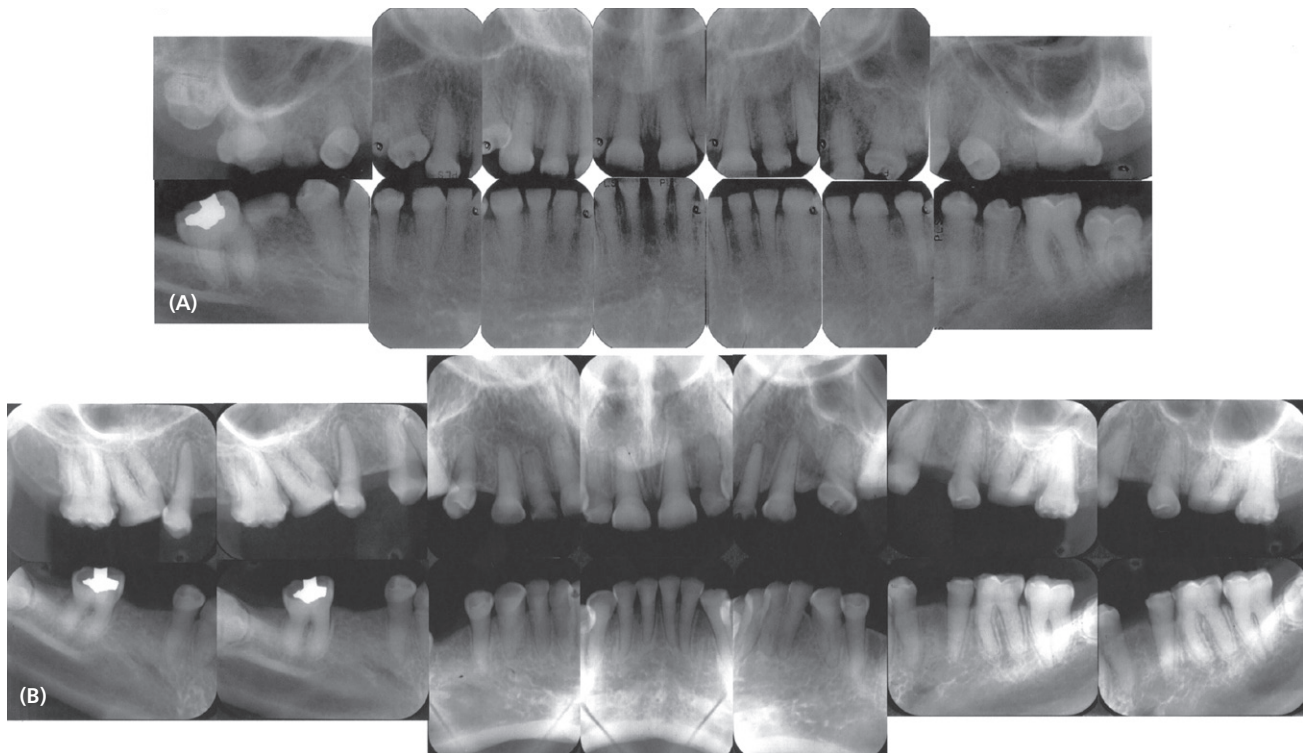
Radiographic records taken at the initial visit and post-orthodontic treatment. A. Full-mouth radiographs taken at age 12 years and 9 months revealed a mixed dentition with overretained primary molars A, J, and T and congenitally missing teeth 1, 4, 13, 16, 29, and 31. The teeth are generally small and their pulp chambers are obliterated. Among the incisors, the enamel appears to be thin and absent from incisal edges. B. Full-mouth radiographs taken post orthodontic treatment at age 17 years and 3 months.
